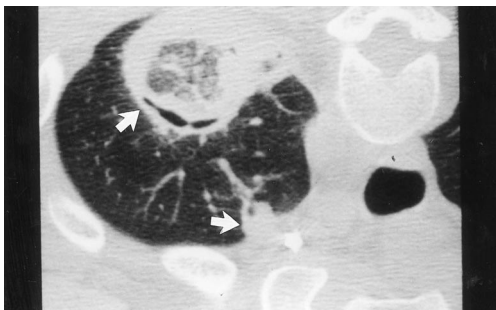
Advanced cavitary, pleural-based aspergilloma lesions on computed tomograph of the chest.
